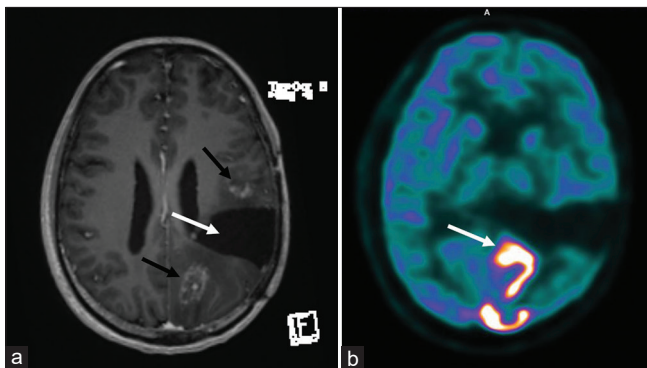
Hybrid magnetic resonance-positron emission tomography imaging at the initial presentation 8 months after completion of the chemoradiotherapy. (a) Contrast-enhanced magnetic resonance imaging showing evidence of patchy areas of enhancement (black arrow) adjacent to the postoperative cavity (white arrow). (b) F-18 flourodeoxyglucose positron emission tomography image showing intense gyral uptake in the left parietal lobe (white arrow). Note that the uptake on F-18 flourodeoxyglucose is not corresponding to the areas of contrast enhancement
